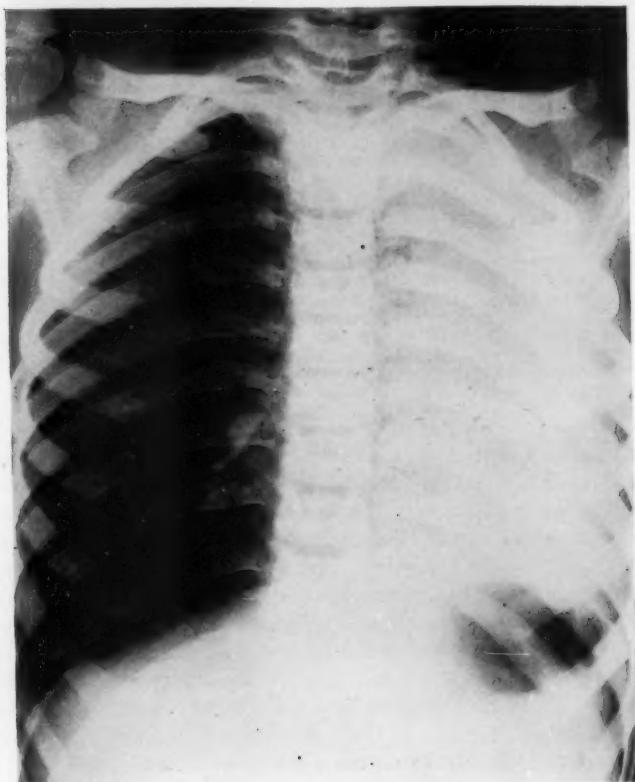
Case 2. Chest Roentgenogram showing evidence of collapse of left lung.
